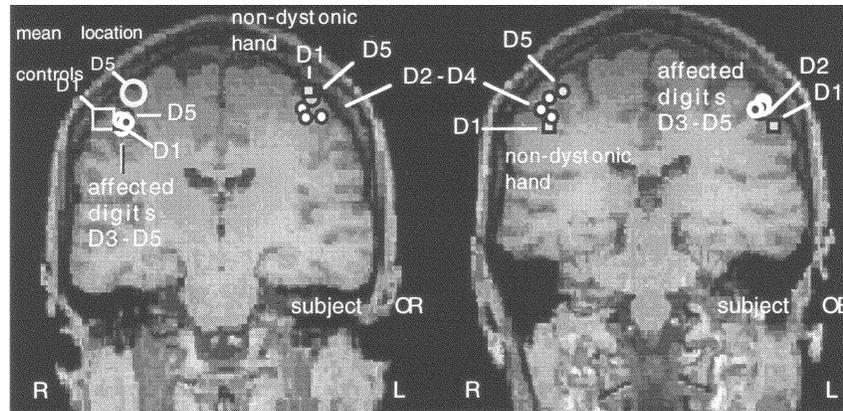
A coronal MRI section is shown through the somatosensory cortices of an organ player (*left*) and an oboist (*right*), both suffering from focal hand dystonia. The symbols indicate cortical representations (dipole locations) of digits 1–5 (D1 to D5) resulting from contralateral stimulation of the finger tips. The large *open symbols* in the right hemisphere of subject O.R. indicate the mean location of dipoles for D1 and D5 in normal control subjects. (Modified from Elbert *et al.*³⁹)
